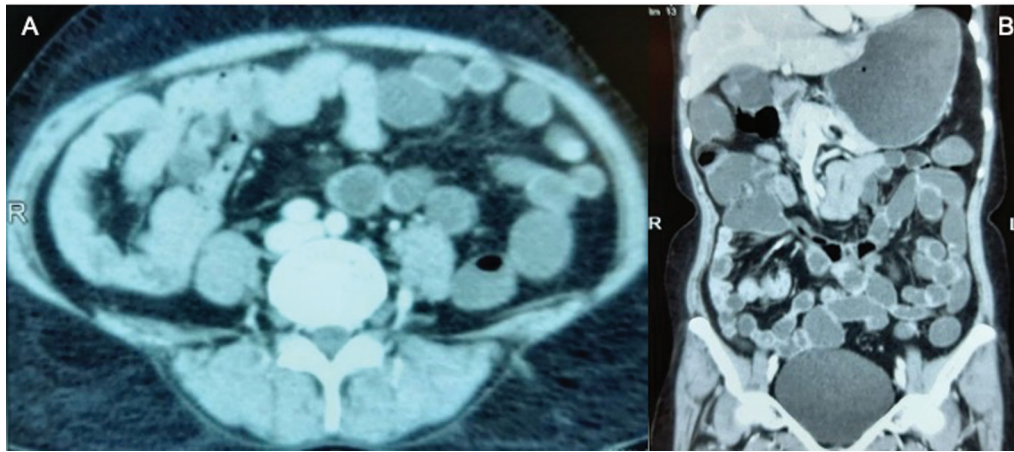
(A, B) Follow-up (at 3 months) CT abdomen showing normal bowel with no residual lesions.
